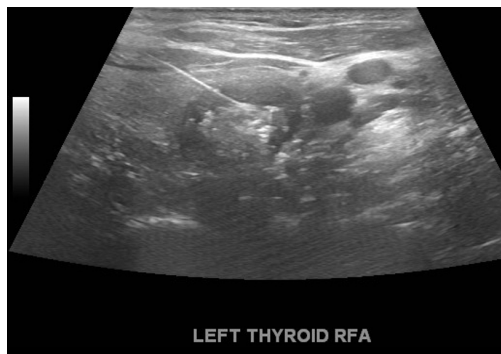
Ultrasound guided radiofrequency ablation of a toxic nodule. RFA, radiofrequency ablation.
